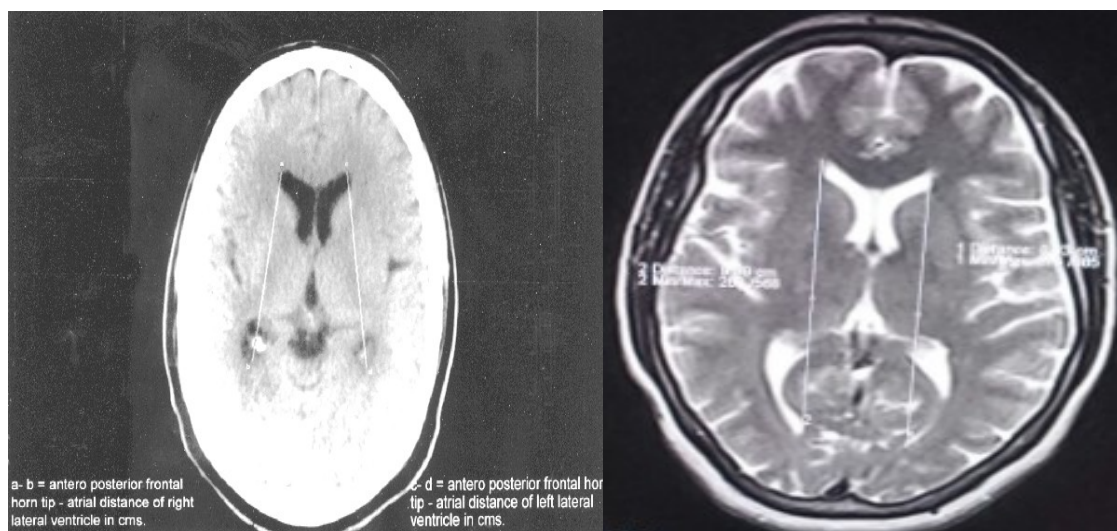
Level above the interventricular foramen showed our length of lateral ventricular measures in Right image (axial MRI)
